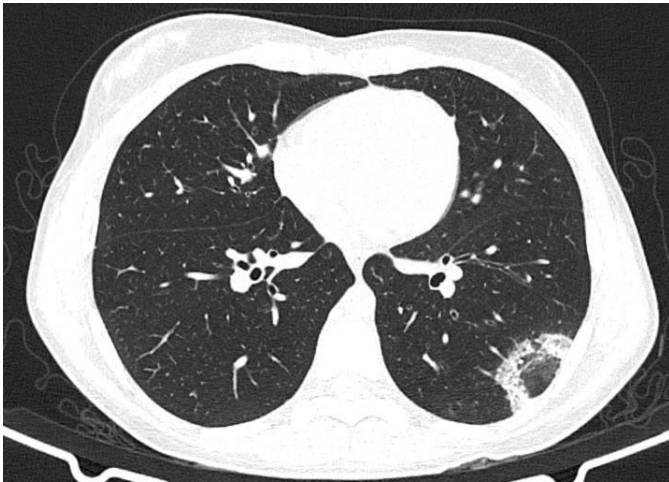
CT-scan (axial plane) showing a subpleural consolidation with a reversed halo sign image (ground glass center with a surrounding consolidation) in the left lower lobe
